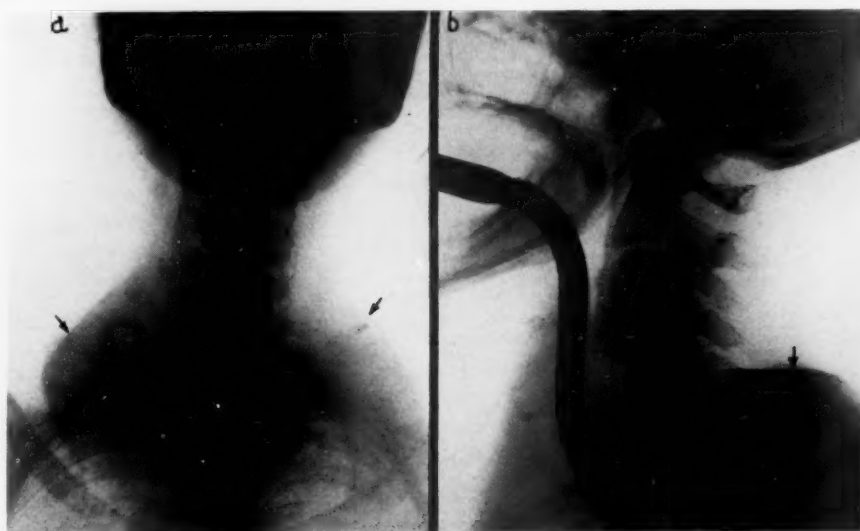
(a) and (b).—These roentgenograms show the spiral-walled, flexible metal catheter introduced into the trachea. (a) Anteroposterior view; and (b) lateral view. Note in (a) the extent of the goiter and the deviation of the trachea. One can readily understand, in this type of large adenomatous goiter as well as in exophthalmic goiter, how manipulation to the trachea can be carried on with no interference with the airway.
